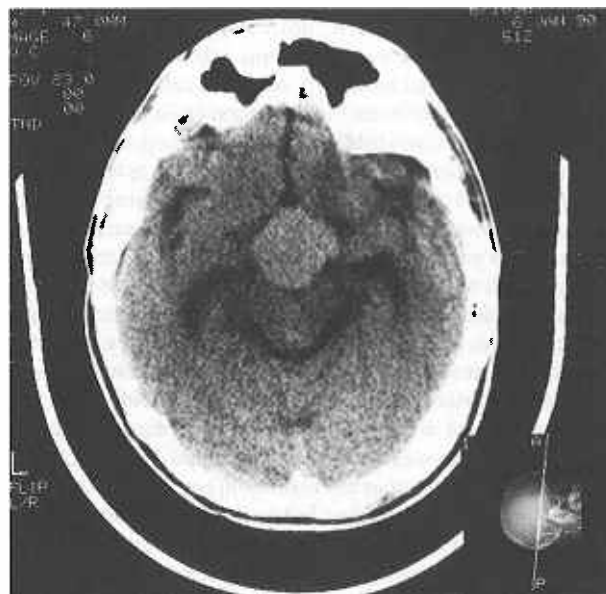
CT scan showing extension of tumour around ventricles with obstructive hydrocephalus.
